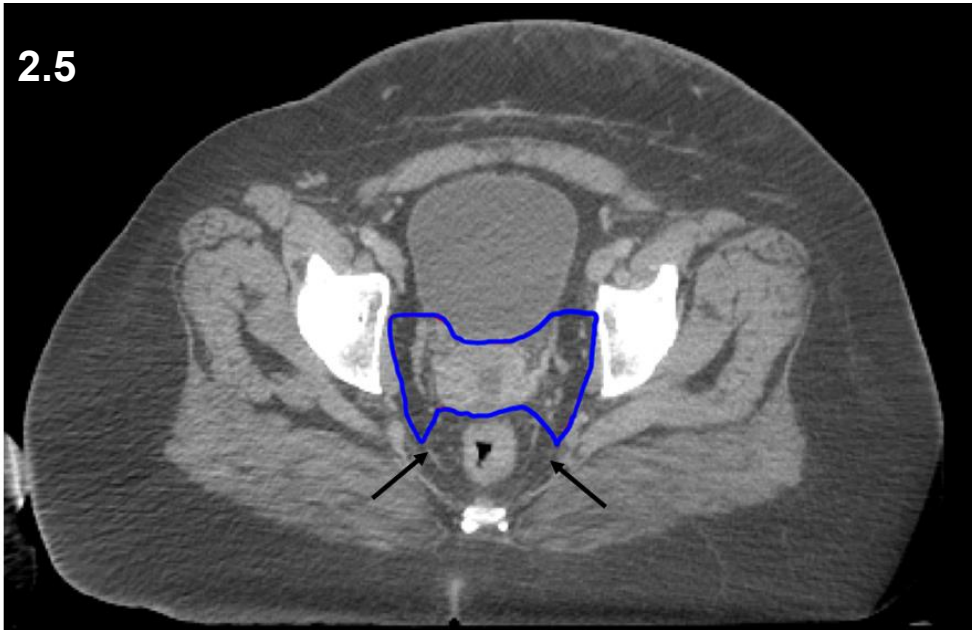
Transverse CT demonstrating the uterosacral ligaments (arrowed) and CTV1 (outlined).
